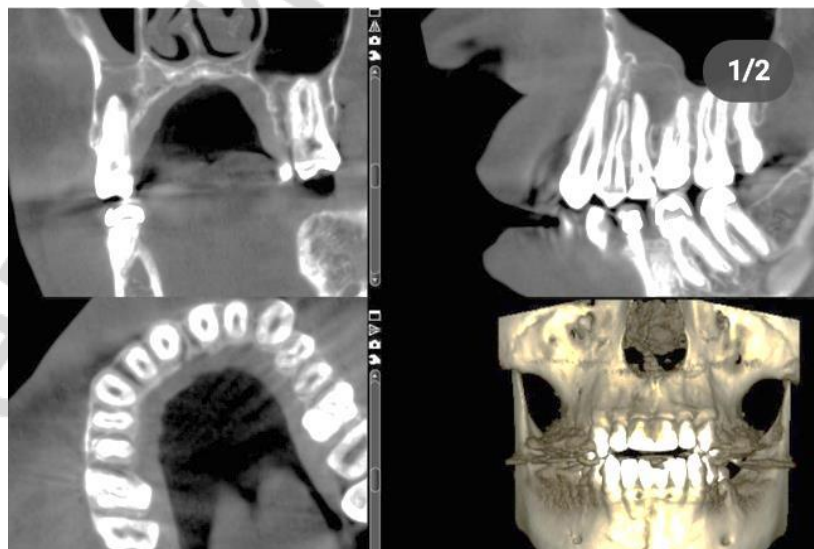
Preliminary X-ray examination
